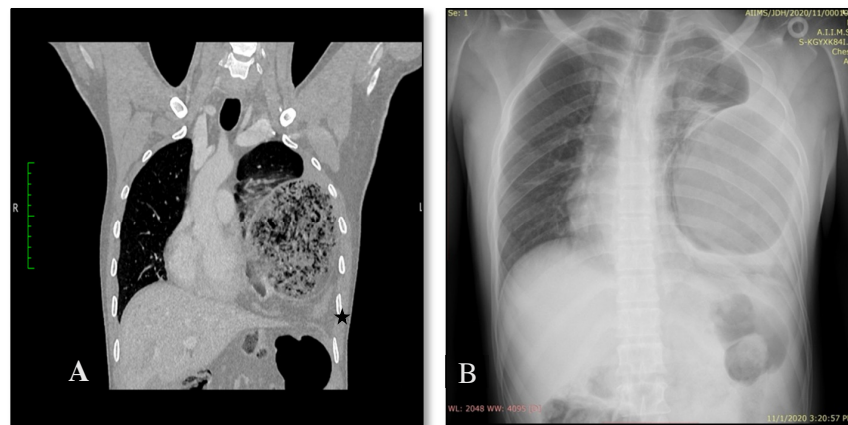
A- Coronal section of CT Thorax suggestive of Diaphragmatic rupture with herniation of the stomach into the thorax
